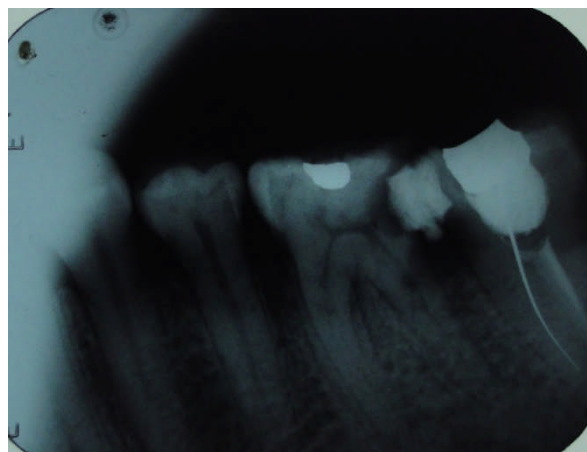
pre operative radiograph of case 2
